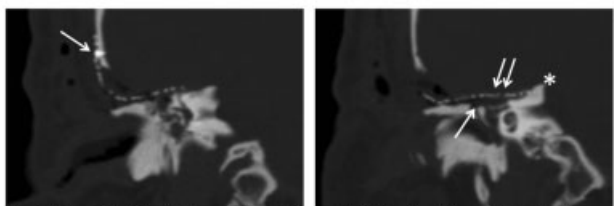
Coronal CT of the right temporal bone (left image) "Gull wing" technique with lateral fixation (white arrow) (right image) Complete titanium mesh (double arrows) reconstruction of the large defect (single arrow) to the petrous ridge (asterisk)
